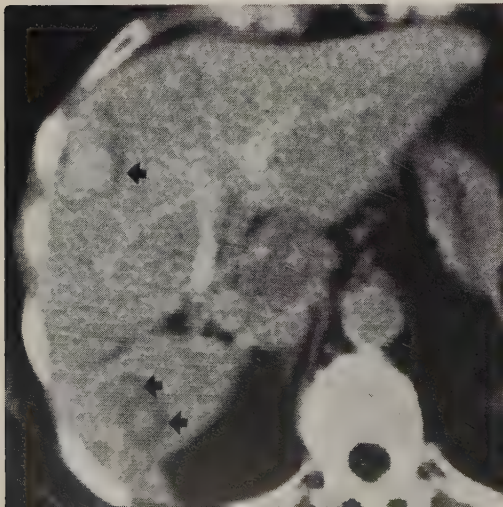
Liver metastasis from colon carcinoma. CT enhanced by contrast injection into hepatic artery. Low-density rings in the periphery of tumor nodules (arrows).
